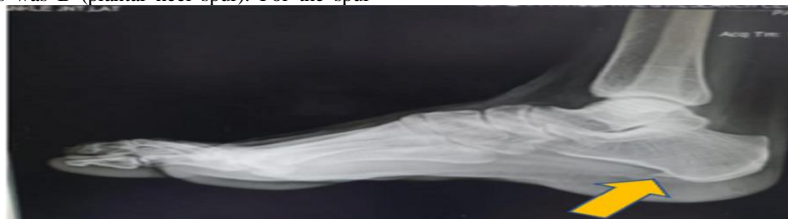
Plain radiograph of right ankle and foot- lateral view showing plantar heel spur
